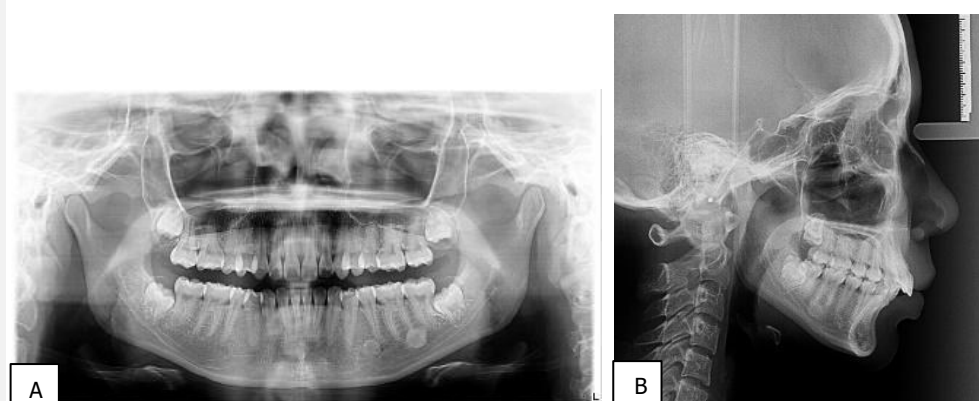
A. Pre-treatment panoramic radiograph showed unerupted maxillary third molar. B. Pre-treatment lateral cephalogram radiograph showed patient having protrusive maxillary incisor
